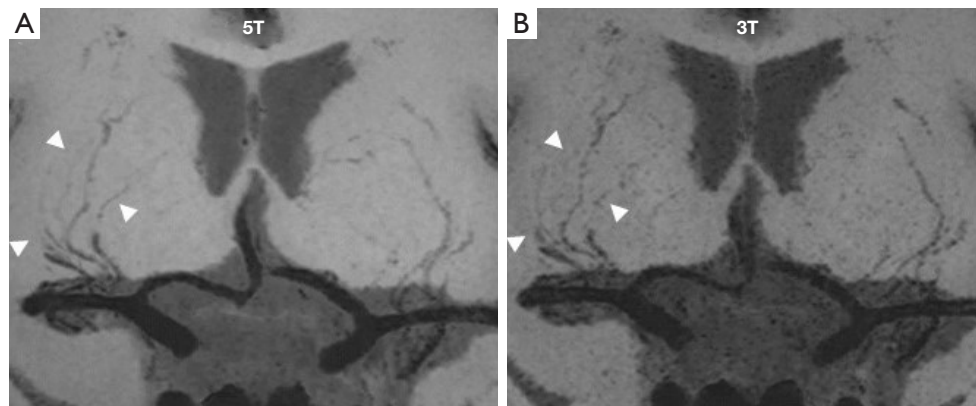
Vascular wall images of Lenticulostriate arteries (LSAs) from obtained by a T1-weighted three-dimensional MATRIX sequence a healthy volunteer (39 years old; male; 170 cm; 80 kg). Thin minimum intensity projection across 10 mm slices for the visualization of LSAs at 5T (A) and 3T (B). Distal vessels were better observed at 5T than at 3T, as shown by the white arrow heads. LSAs, lenticulostriate arteries; MATRIX, Modulated flip Angle Technique in Refocused Imaging with eXtended echo train.
